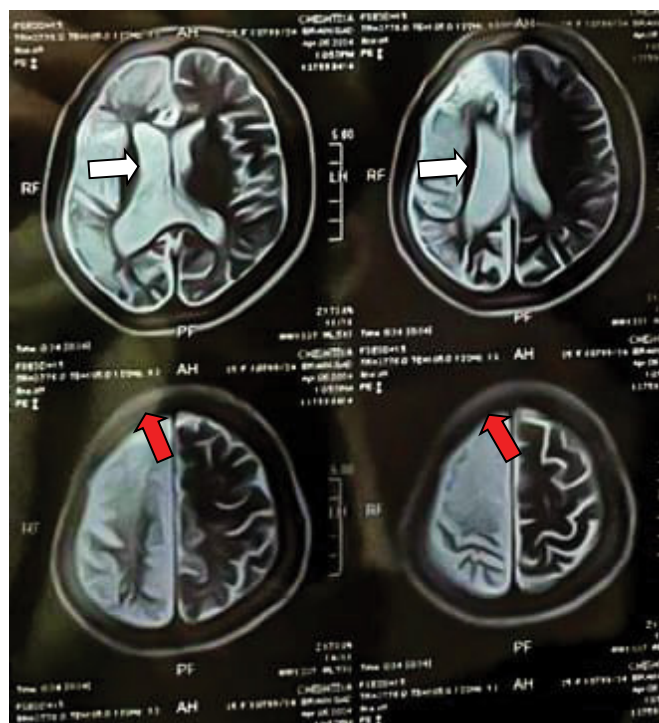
Axial T2-weighted MRI of the brain showing hemiatrophy of the right cerebral hemisphere along with ex-vacuo dilatation of the ipsilateral lateral ventricle (white arrows) and hypertrophy of the right side of calvarium predominantly the frontal bone (red arrows).
